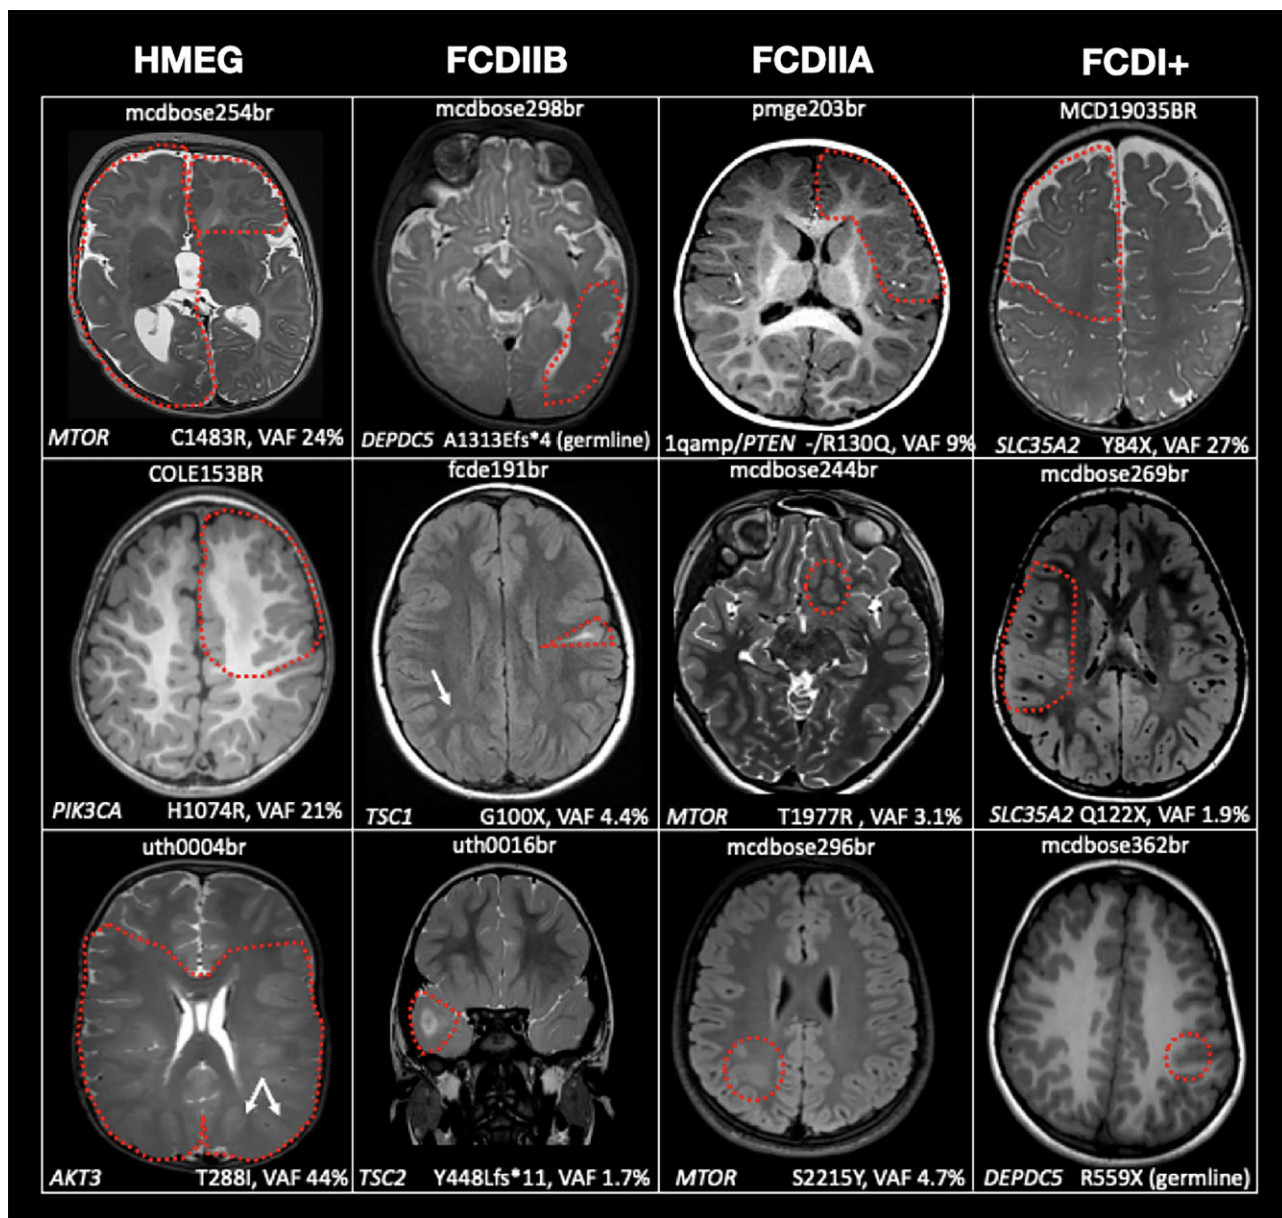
Representative brain MRIs from subjects in the cohort, organized in columns by malformation type (HMEG, FCDIIB, FCDIIA, FCDI+). For each subject (top), the gene, the associated variant and variant allele frequency are provided (bottom). All images are displayed in the axial plane with the exception of uth0016br, which is displayed in coronal, using a mixture of T₁-, T₂- and FLAIR-weighted sequences. The cortical malformation is outlined by a dashed line. For fcd191br and uth0004br, arrows indicate a retrospectively identified transmantle sign in the contralateral hemisphere suspicious for cortical dysplasia and the resected portion of the malformation, respectively.
